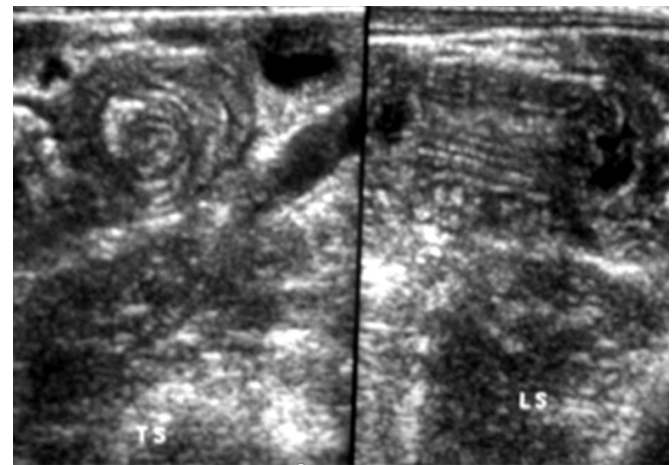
Ultrasonographic picture of intussusception
